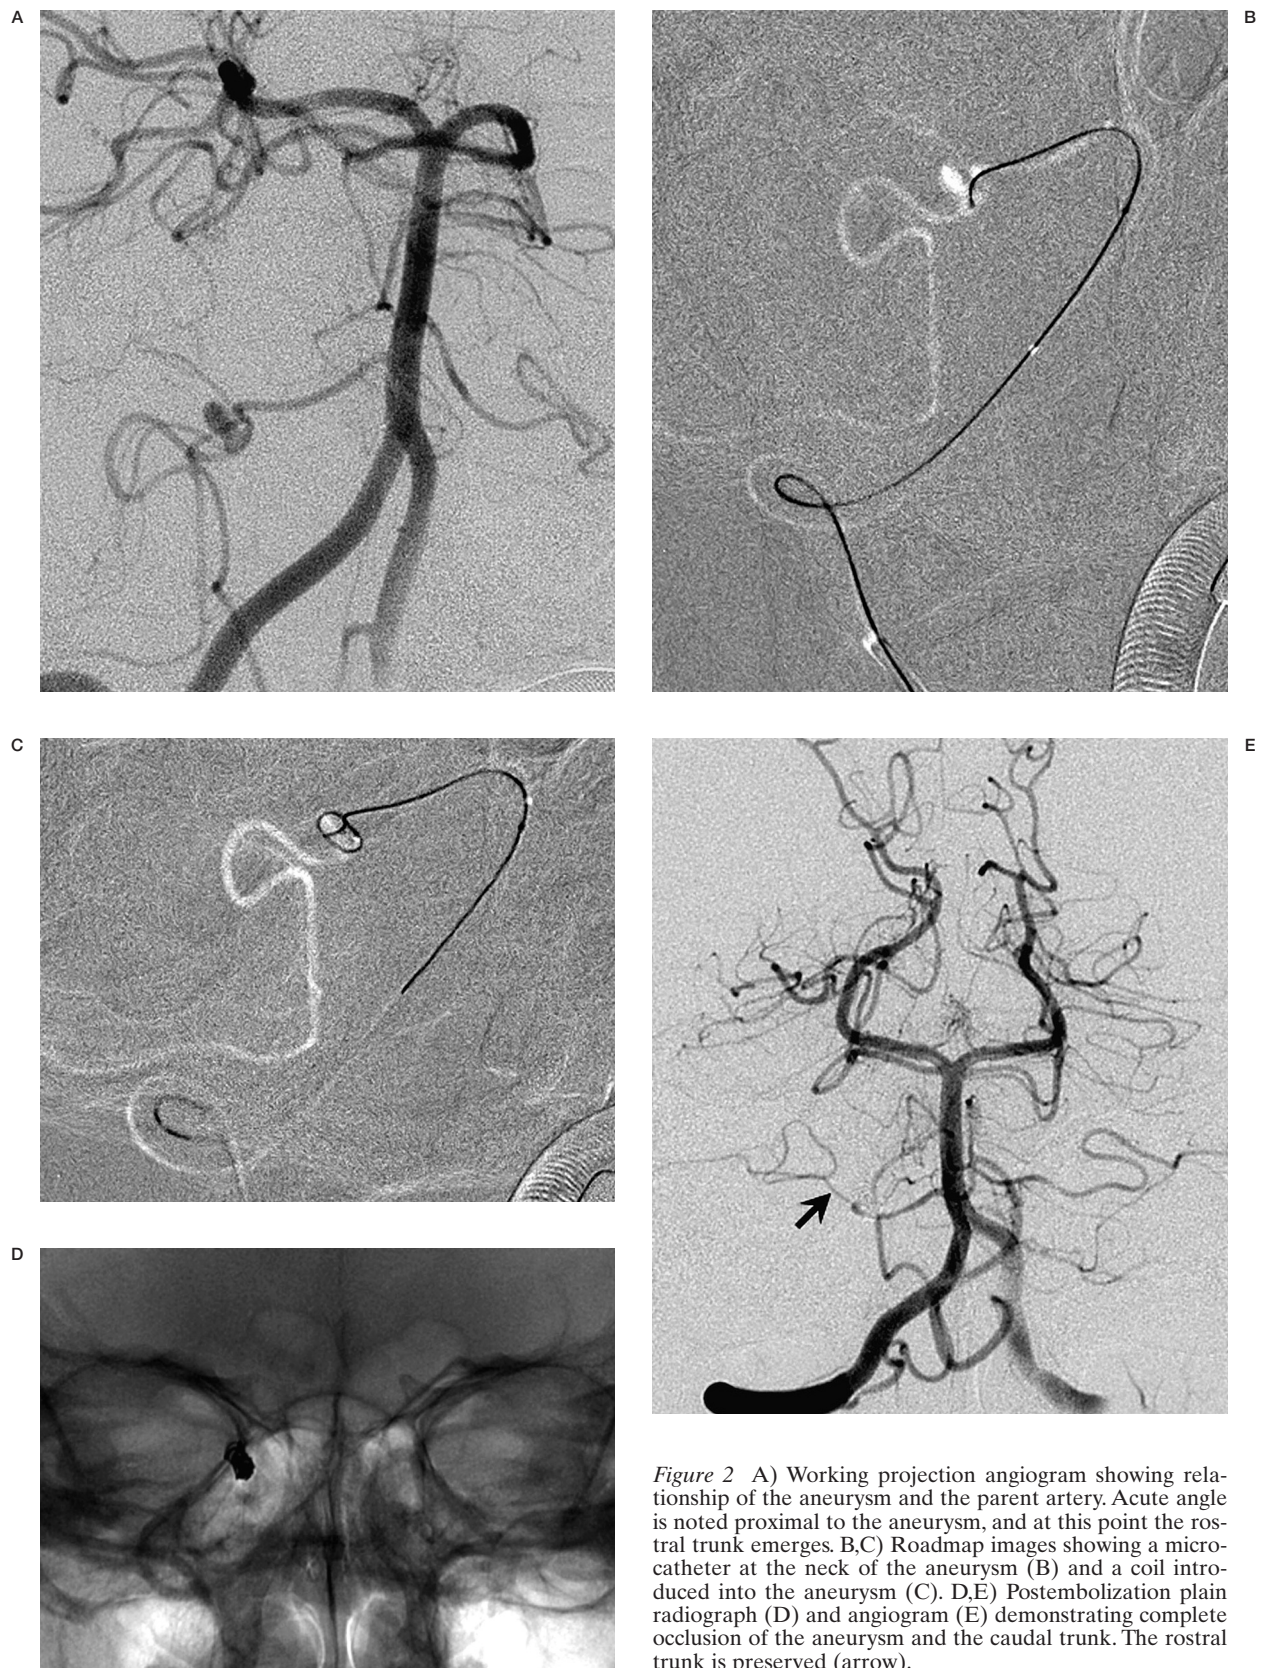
A) Working projection angiogram showing relationship of the aneurysm and the parent artery. Acute angle is noted proximal to the aneurysm, and at this point the rostral trunk emerges. B,C) Roadmap images showing a microcatheter at the neck of the aneurysm (B) and a coil introduced into the aneurysm (C). D,E) Postembolization plain radiograph (D) and angiogram (E) demonstrating complete occlusion of the aneurysm and the caudal trunk. The rostral trunk is preserved (arrow).
